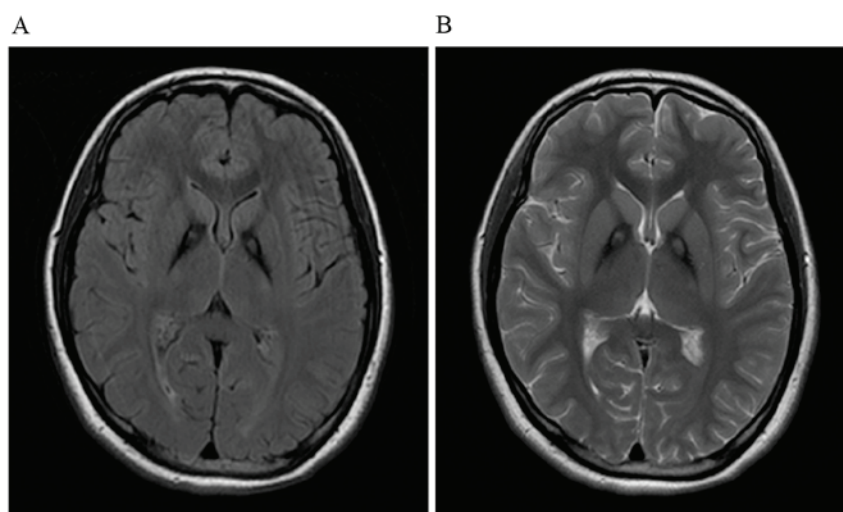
Axial magnetic resonance imaging demonstrates bilateral hyperintense pallidal areas on background areas of T2 shortening, termed eye-of-the-tiger sign. (A) T2-fluid attenuated inversion recovery and (B) T2-weighted.
